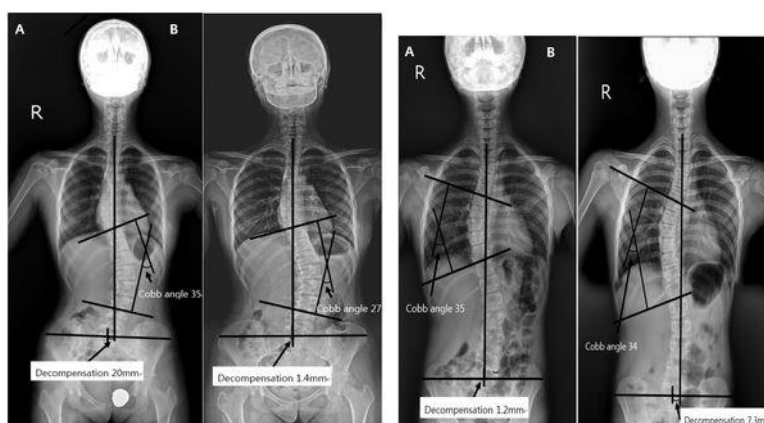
X-ray of patient 1. (A) Before brace (B) After 6 months Boston brace treatment without brace
